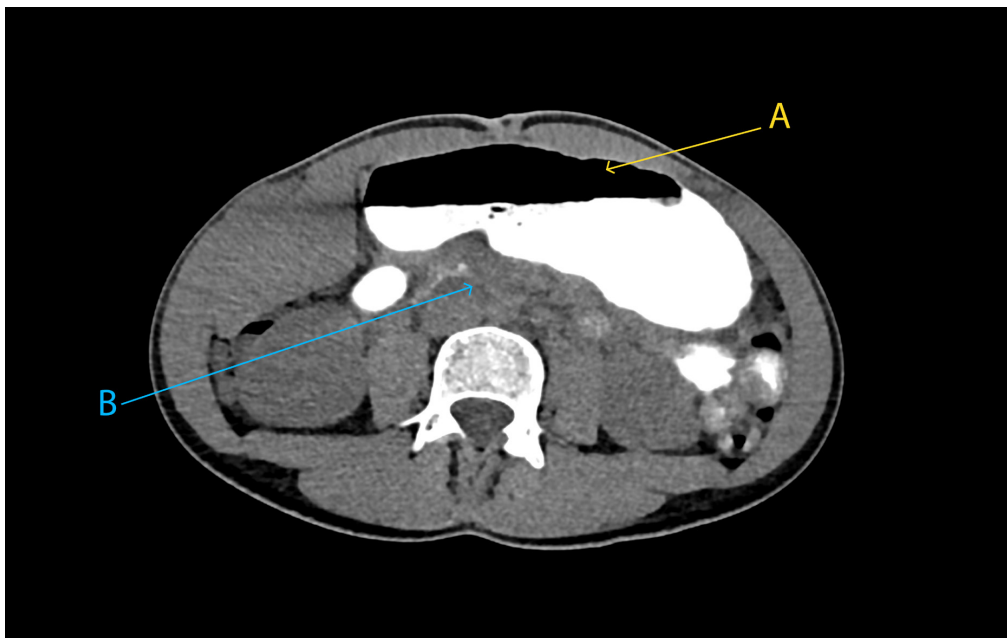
Abdominal computed tomography with oral contrast (axial view) demonstrating marked gastric dilatation (yellow arrow A) and compression of the third portion of the duodenum (blue arrow B).
